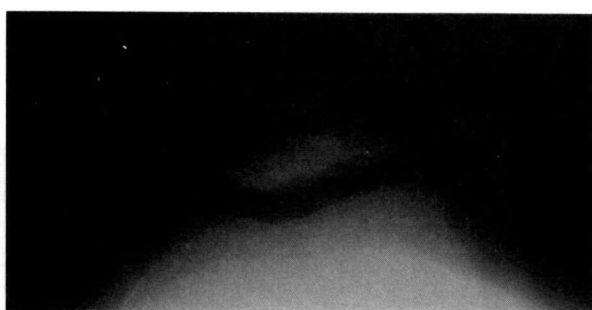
A postoperative roentgenogram of the knee in case 1. : The tilting angle improved to 7° and the lateral shift ratio was improved to 20%.
